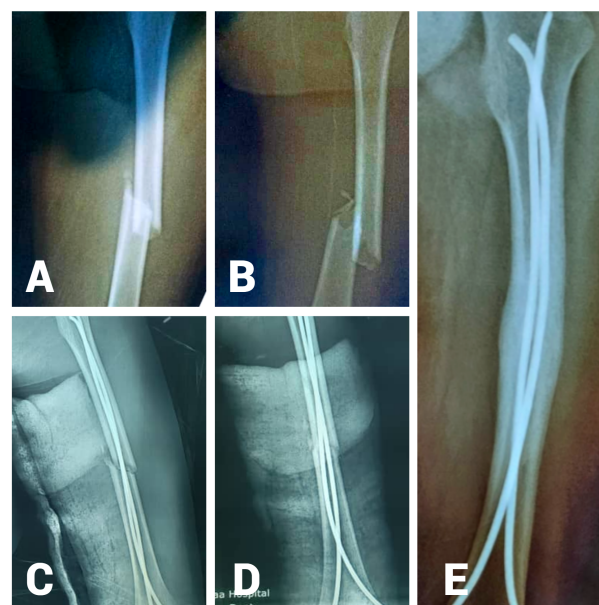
Radiographs of a 9-year-old male with a left femoral shaft fracture treated with TENS. (A) Anteroposterior (AP) and (B) lateral preoperative radiographs showing a transverse fracture of the femoral shaft. (C) AP and (D) lateral immediate postoperative radiographs demonstrate excellent alignment and reduction with two TENS nails. (E) Follow-up AP radiograph at 12 weeks showing bridging callus formation, indicating solid fracture union.
